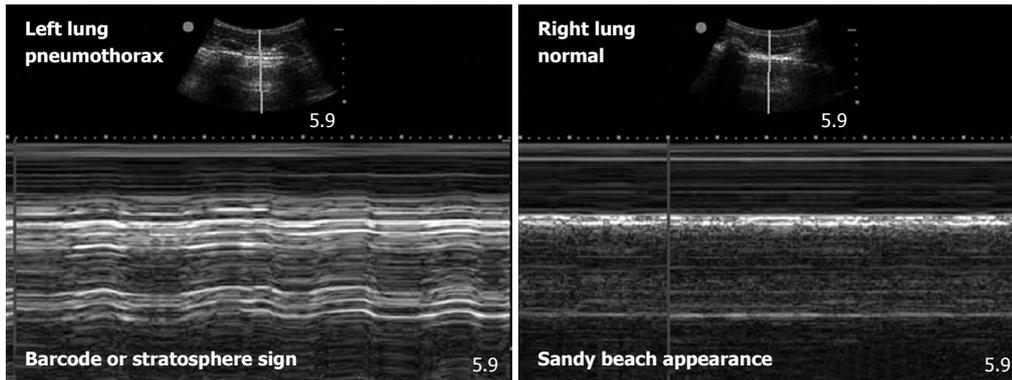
Pneumothorax on bedside ultrasonography. These two images utilize M-mode echography to gather more information on the pleural interfaces seen as a hyperechoic line in the B-mode images above. The M-mode tracings below represent a single line of sight through the B-mode images. Over time, the gray-scale appearance of M-mode images changes with the movement of the tissue. In normal lungs the pleurae slide across each other and this movement takes on a “granular” or “sandy beach” appearance (image on the right). As a result of the lack of pleural sliding in the presence of pneumothorax, a pattern of horizontal striations that do not demonstrate the granular appearance of movement is present. This M-mode pattern that is characteristic of pneumothorax has been described as a “barcode” or the “stratosphere” sign (image on the left).
